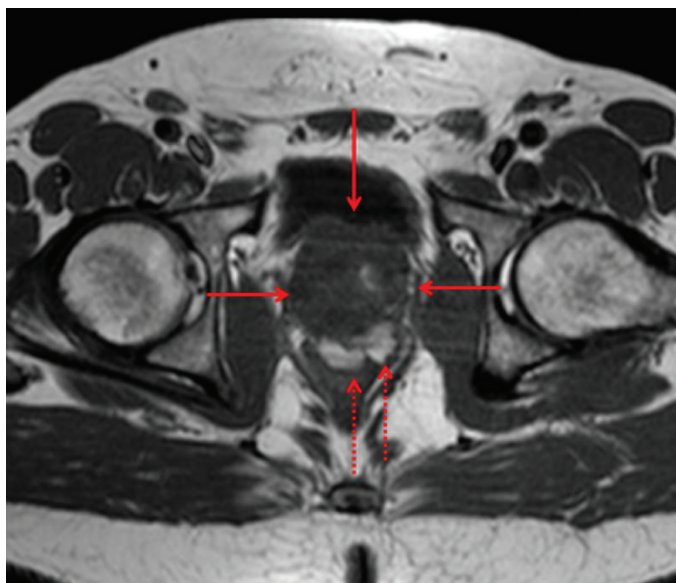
Axial turbo spin echo T1-weighted image reveals central and peripherally hyperintense areas (stippled arrows) within the mass (red arrows) compatible with mucin lakes
